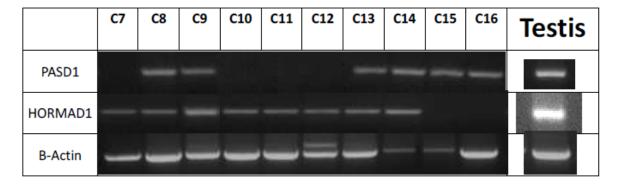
Representative agarose gel image of PCR amplification of CTA gene transcripts in oesophageal OAC patients
